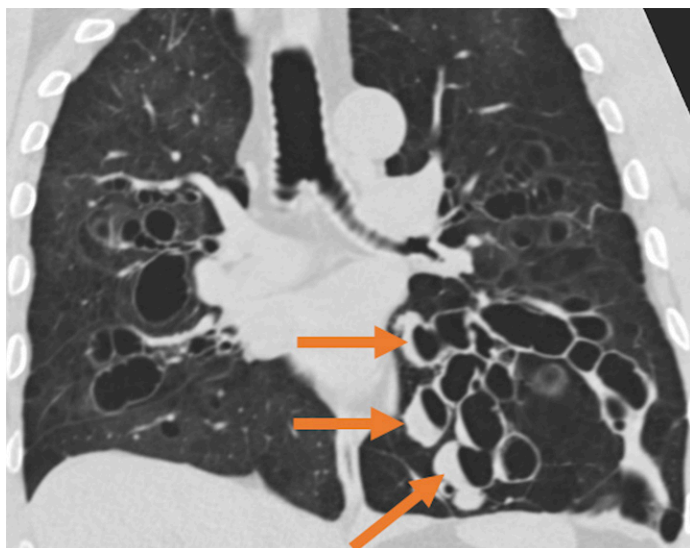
Coronal CT image shows marked cystic bronchiectasis and bronchial wall thickening, predominantly involving the third- to sixth-order bronchi. Left lower lobe endobronchial air-fluid levels and bronchial wall thickening suggest superimposed infection (arrows). Sputum cultures showed *Pseudomonas aeruginosa*.
